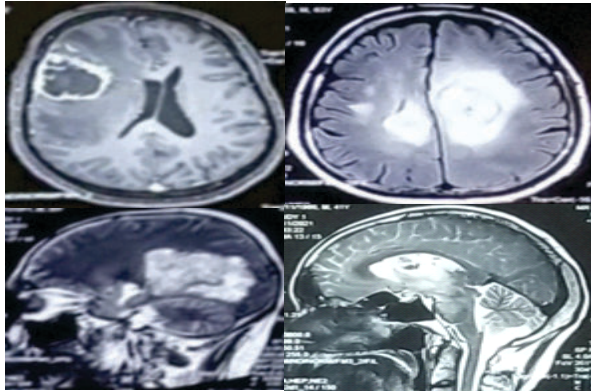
MRI images of 4 different GBM patients. A) Axial view- Gliosarcoma involving lesion in right frontal lobe, B) Axial view- Butterfly glioblastoma involving lesion in left fronto-parietal, thalamic and periventricular white matter, corpus callosum, basal ganglia and right parietal lobe. C) Left sagittal view- Lesion in parieto-temporo-occipital lobes. D) Left sagittal view- Lesion in parieto-temporal lobes, periventricular region, midbrain and pons.
